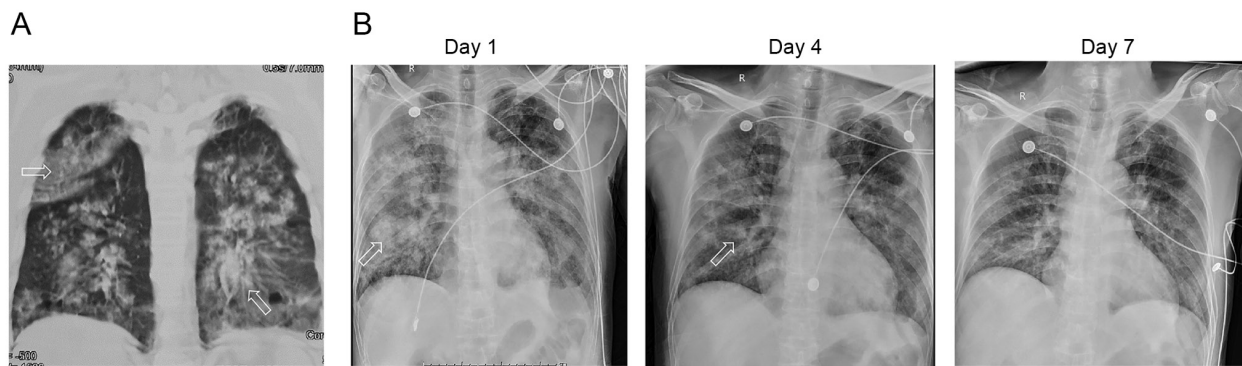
Imaging features of Case 1. (A) Chest CT scan showed diffuse exudative patchy shadows in both lungs. (B) X-rays showed improvement of pulmonary exudative lesions from days 1 to 7 after treatment. The arrows represent the exudative changes in the lungs.
